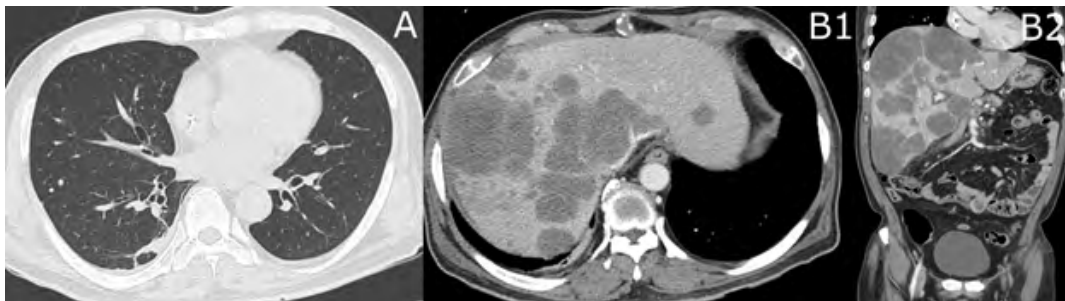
(A) Chest computed tomography (CT) discovered multiple metastatic nodules in both lungs (B1) Coronal and (B2) sagittal abdominal CT showed extensive liver metastasis.
